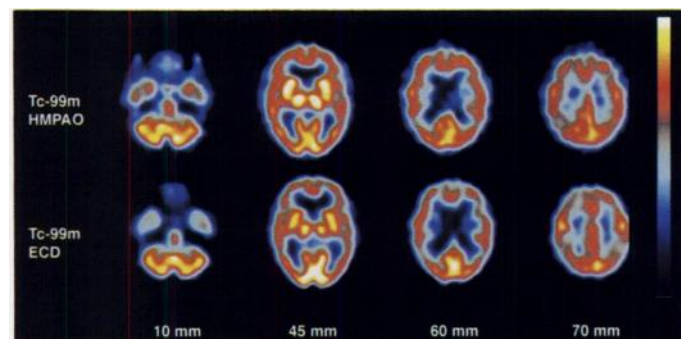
Cerebral SPECT images for a 67-yr-old woman with probable AD using ^{99m}Tc -HMPAO and ^{99m}Tc -ECD. The ^{99m}Tc -ECD images demonstrate greater contrast than ^{99m}Tc -HMPAO between “typically affected” and relatively “unaffected” brain regions. This difference is most evident in the 70-mm slice in the comparison between superior parietal association cortex (affected) and sensorimotor cortex (relatively unaffected). The slice 80 mm above the canthomeatal plane is not shown.
